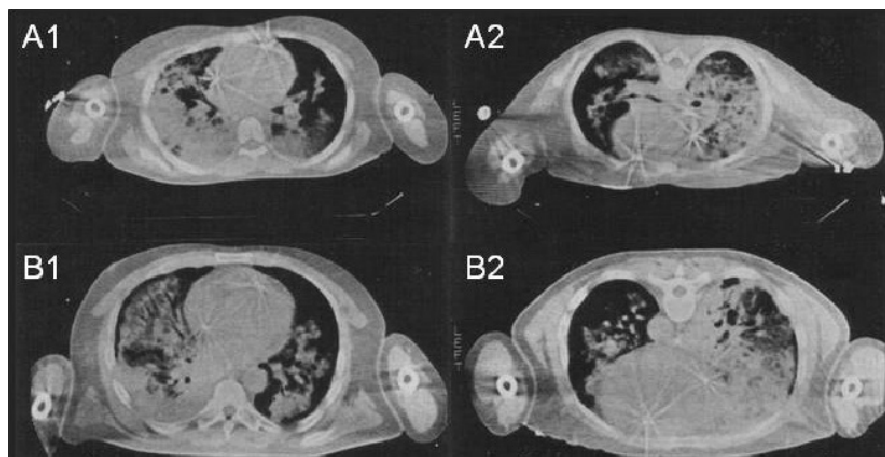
CT scan images of two ARF patients in the supine (A1 and B1) and prone (A2 and B2) position. Published with permission from [28]
